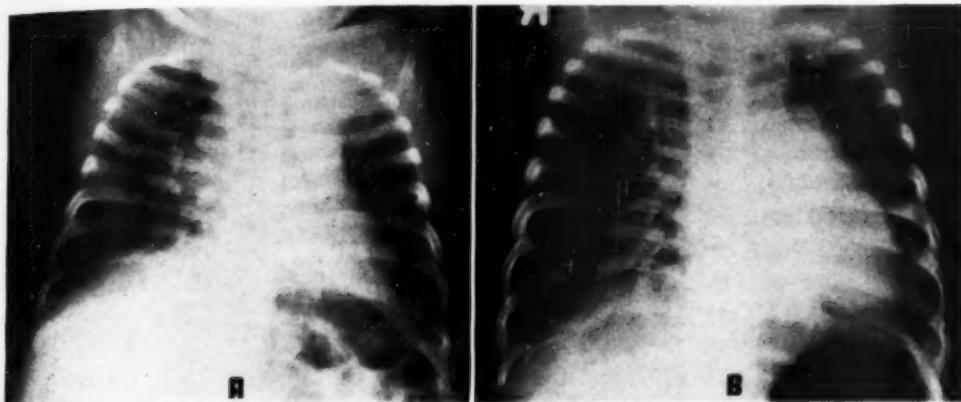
Case I. A. Roentgenogram at three months of age, showing widening of superior mediastinal shadow due to left upper lobe atelectasis. B. Roentgenogram at seven months of age, one day before death, showing marked emphysema of the right mid-lung field and atelectasis of the right upper lobe. The left upper lobe was also thought to be emphysematous, with segmental atelectasis.
